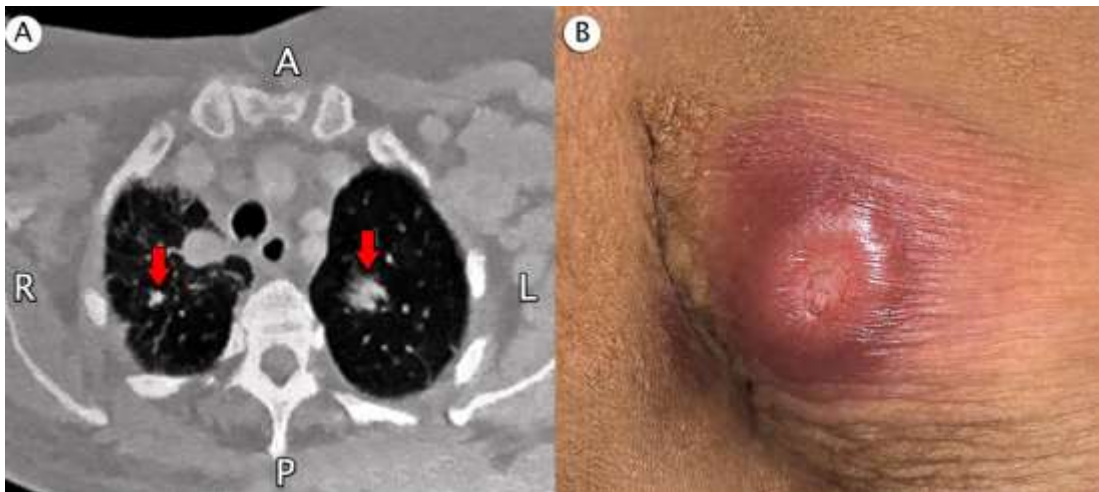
A. Chest CT Scan Showing several spiculated masses on both lung fields (red pointers), suggestive of metastases. Anterior (A), left (L), posterior (P), right (R) of the patient; B. Appearance of new erythematous, ulcerated, firm, tender nodule at the left axilla, measuring 1.5cm x 1cm x 1cm seen during the course of treatment.
